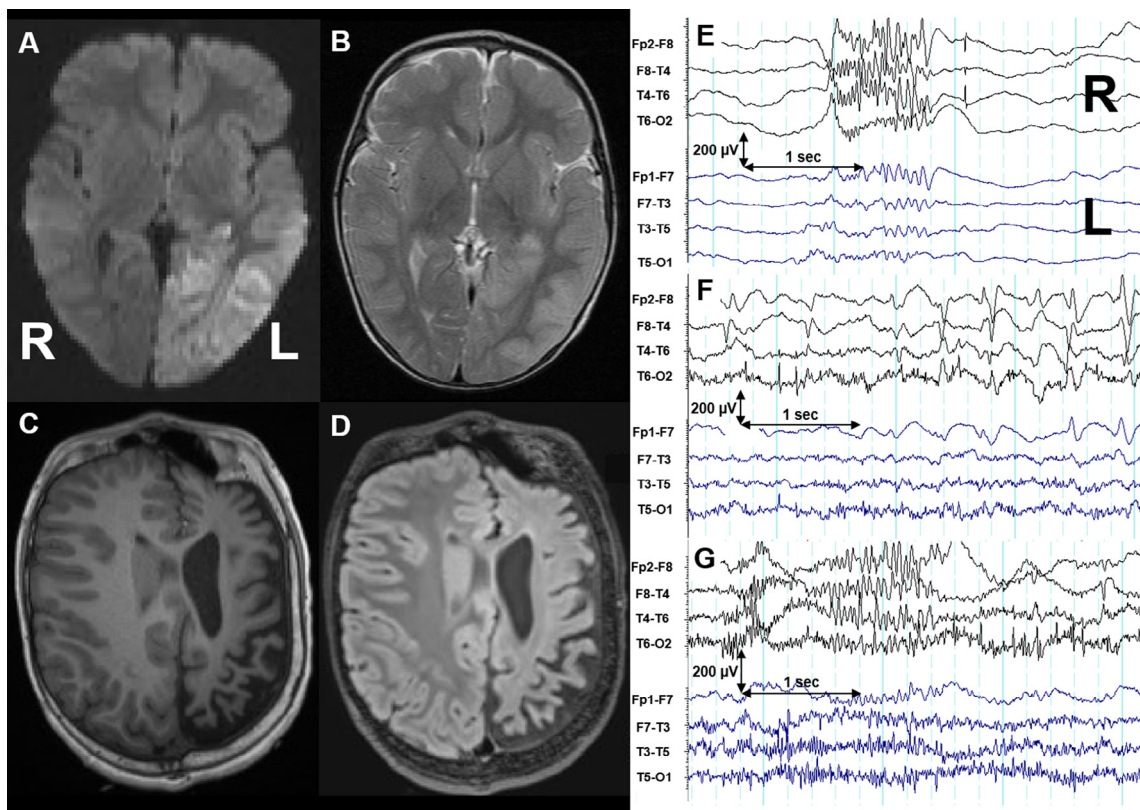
Magnetic Resonance Imaging and Electrophysiology: Brain MRI three days after initial presentation (23 months of age) shows cytotoxic edema over the posterior left hemisphere demonstrated by restricted diffusion on axial diffusion-weighted imaging (A) and increased signal with swelling on axial T2-weighted sequences (B). At 9 years, diffuse left hemispheric atrophy is seen on axial T1-weighted and fluid attenuation inversion recovery sequences, with normal-appearing right hemisphere (C, D). Interictal EEG shows right hemispheric sharp waves and paroxysmal fast activity (E), and runs of 1–2 Hz frontally-predominant slow spike-wave discharges (F). Ictal EEG during a tonic seizure initially shows diffuse fast activity, maximal over the right hemisphere, evolving to slowing over the right hemisphere (G).
